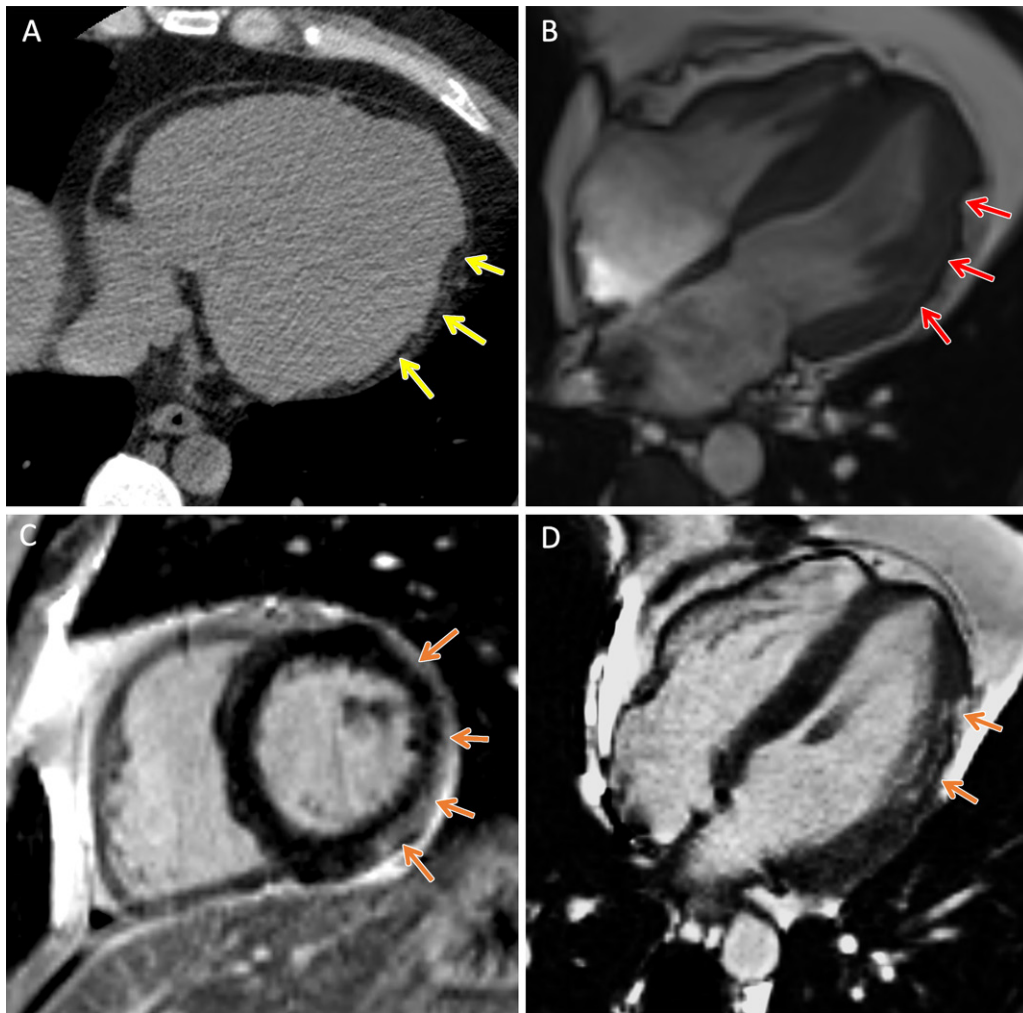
TMEM43* arrhythmogenic cardiomyopathy. Cardiac CT and MR images in a male patient between 30 and 39 years of age (exact age not provided due to potential reidentification risk) with a *TMEM43* variant of unknown significance (p.Gly280Glu) with palpitations and premature ventricular beats at Holter monitoring. (A) Axial noncontrast cardiac CT image demonstrates extensive subepicardial fat along the lateral left ventricular wall (yellow arrows). (B) Four-chamber 1.5-T steady-state free precession MR image demonstrates subepicardial chemical shift artifact along the lateral left ventricular wall (red arrows). (C) Short-axis and (D) four-chamber late gadolinium enhancement images demonstrate subepicardial late gadolinium enhancement involving the midventricular anterolateral wall, inferolateral wall, and inferior wall (orange arrows).
